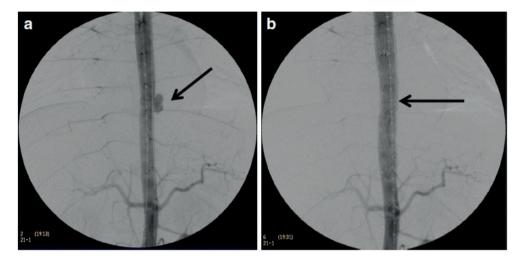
(a) Descending thoracic aortic false aneurysm following a transthoracic gunshot injury (black arrow). (b) Endograft repair with successful deployment of a covered stent (black arrow)
